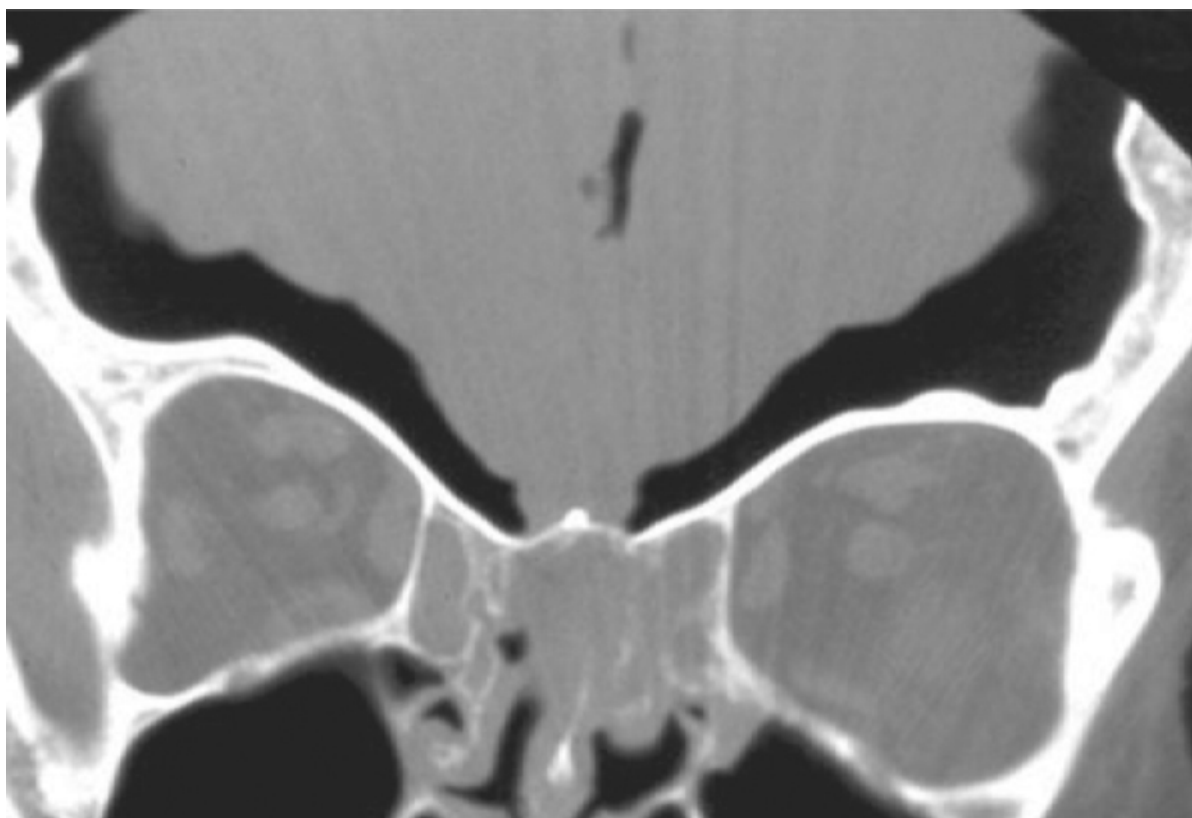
Mental status changes developed in the postoperative period. Computed tomography demonstrated a tension pneumocephalus that required aspiration to relieve frontal lobe compression.
